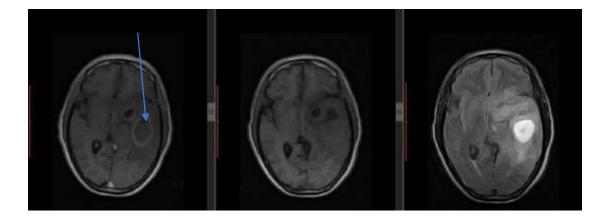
Brain MRI of 42-year-old Female who presented with headache. It showed a well-defined left parietal extra axial mass which was hypointense on T1 and hyperintense onT2. It also had perilesional edema, midline shift and compression of Right Lateral ventricle. This was confirmed to be Meningioma.
